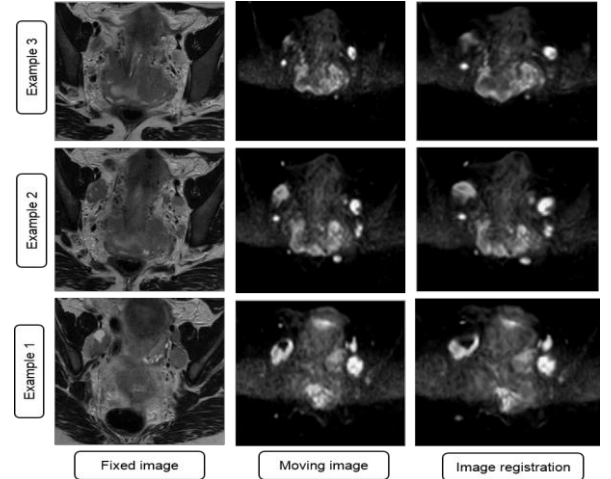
Two types of pelvic MRI images are used: T2-w axial and DW Image. The fixed image is the axial T2-w image, and the moving image is the DW image.
